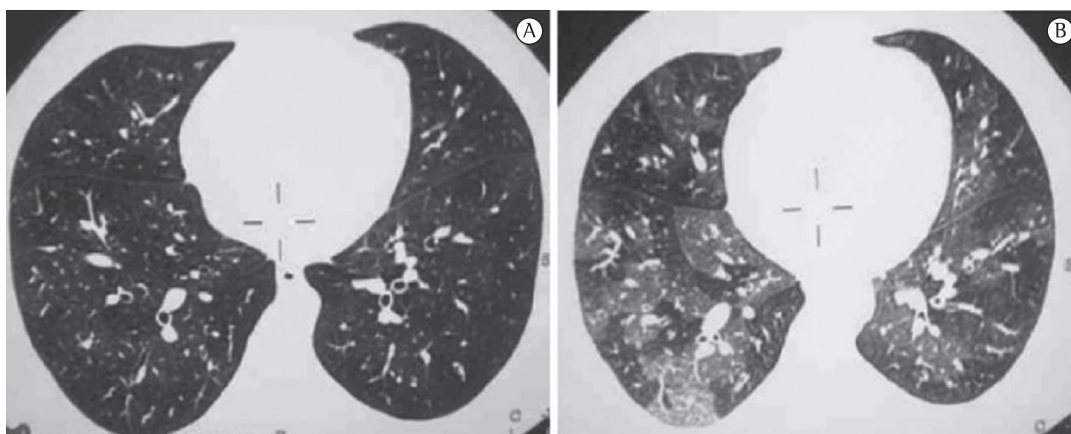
Chest CT scans of case 2 during inhalation (in A), revealing lung hyperinflation and bronchial wall thickening, and during exhalation (in B), revealing a mosaic pattern.
